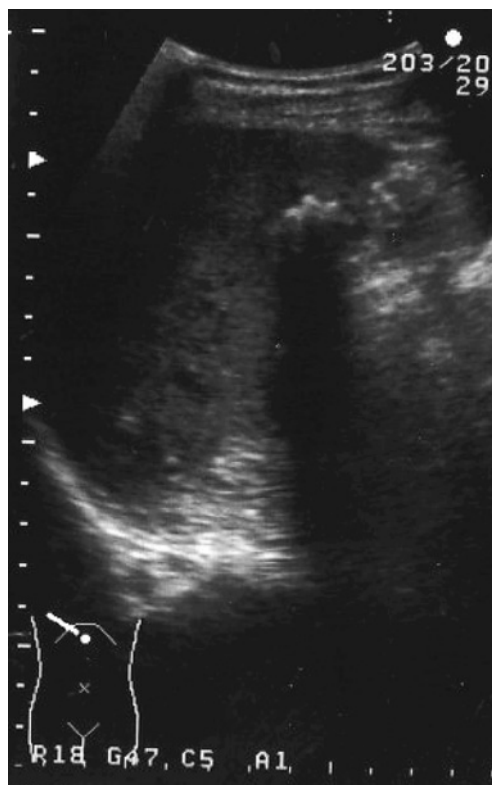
Abdominal ultrasonography showed a hypoechoic lesion measuring 3 cm in diameter with several stones in segment 5 of the liver.
